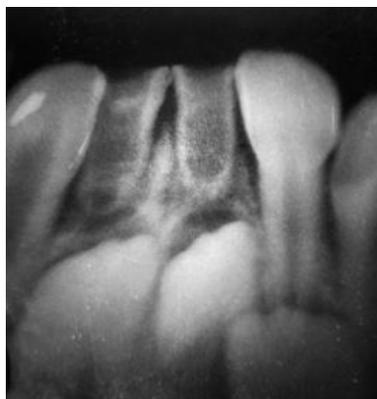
Radiographic image showing large pulp chambers with wide root canals in relation to 71 and 81
